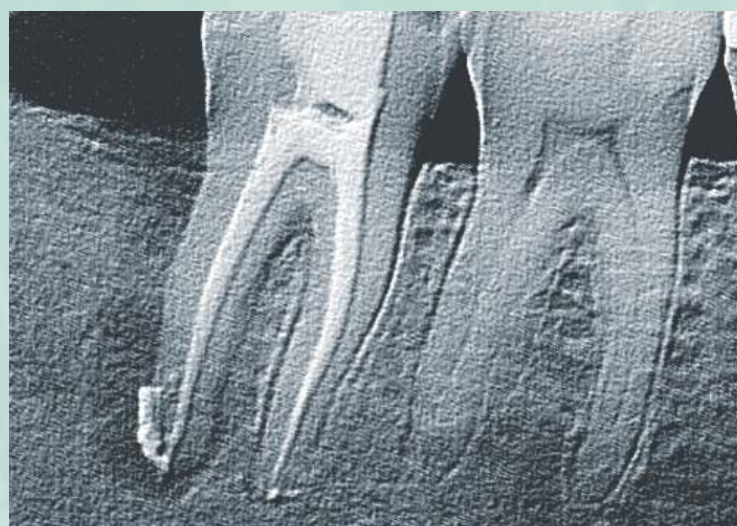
Postoperative radiograph shows bone loss into furcation and length of distal root. A nondisplaceable mesiodistal fracture was found. Surplus sealer was extruded beyond apex of distal root during obturation.
